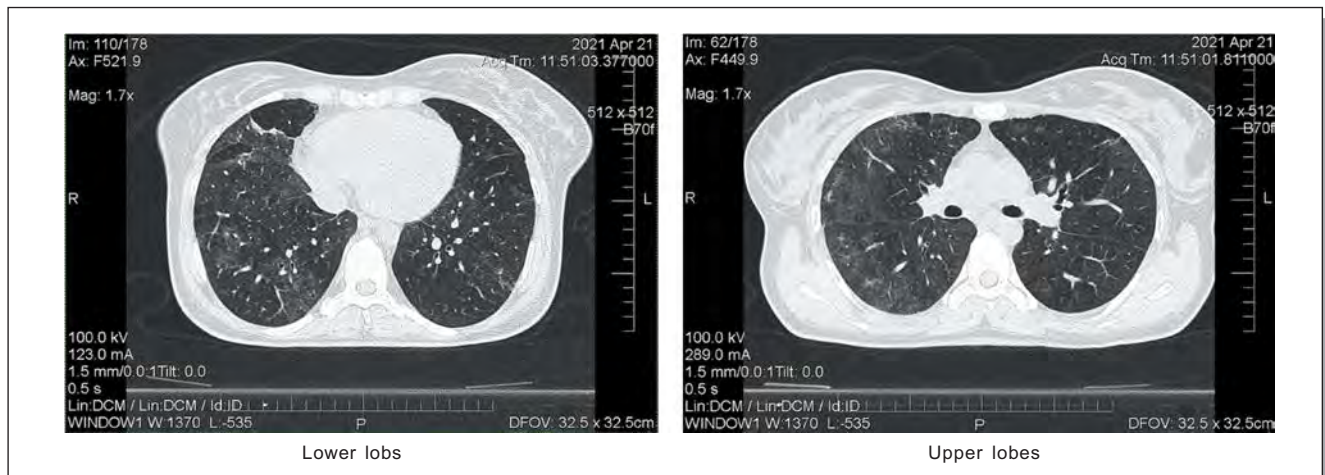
A follow-up CT scan 4 weeks after discharge from the hospital. The confluent compaction of the lung parenchyma had subsided. Reticular changes in the peripheral parts were visible, representing a regression of inflammatory changes
